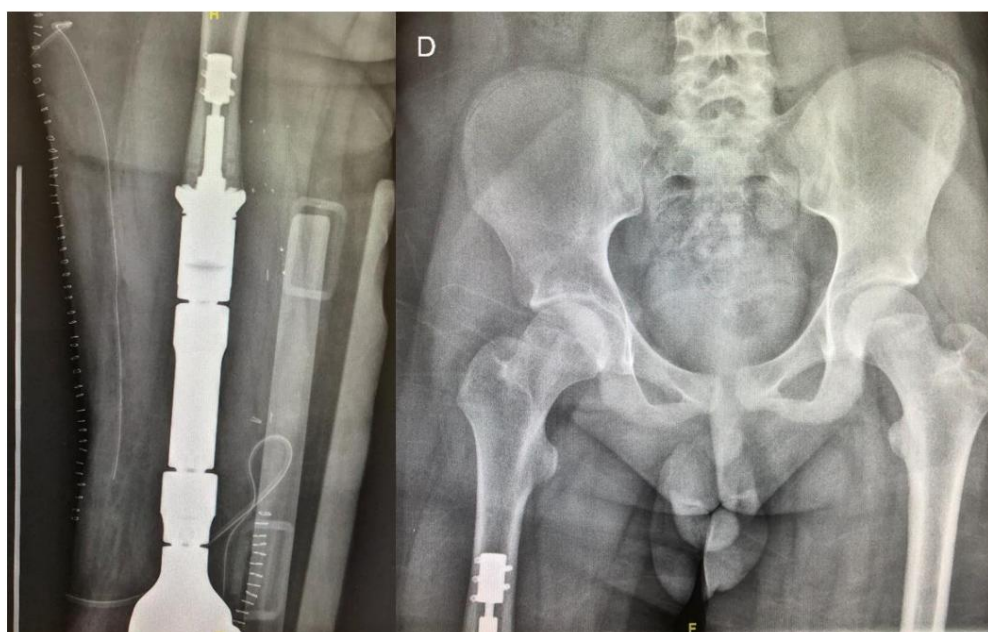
Radiographic control after revision surgery for peri-implant fracture.
